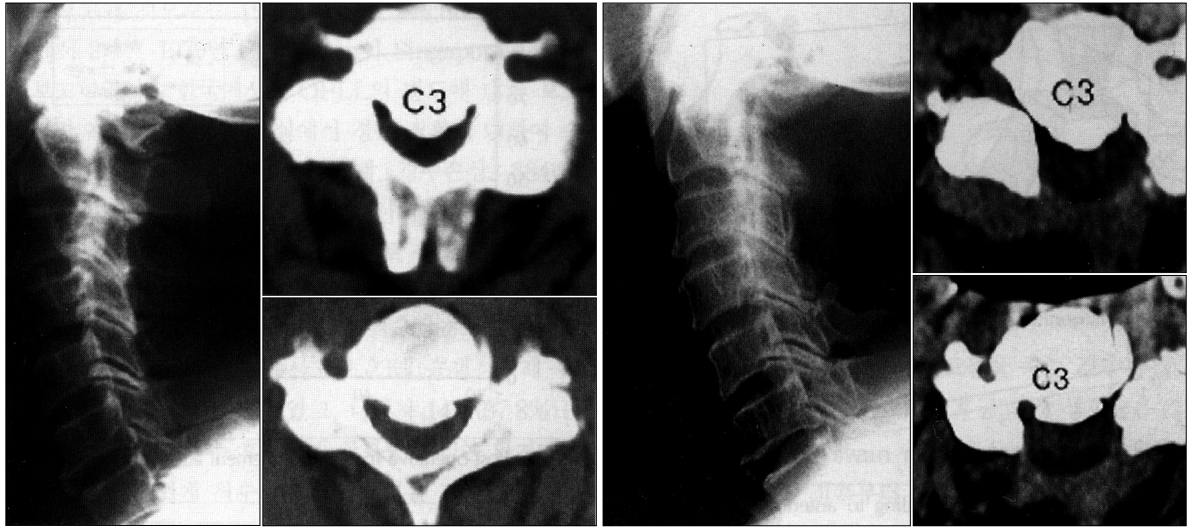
Pre-operative cervical spine lateral X-ray and CT scan demonstrate continuous type OPLL which compresses spinal cord at upper cervical spine level. Post-operative cervical spine lateral X-ray and CT scan show spinal canal expansion after cervical laminectomy.
